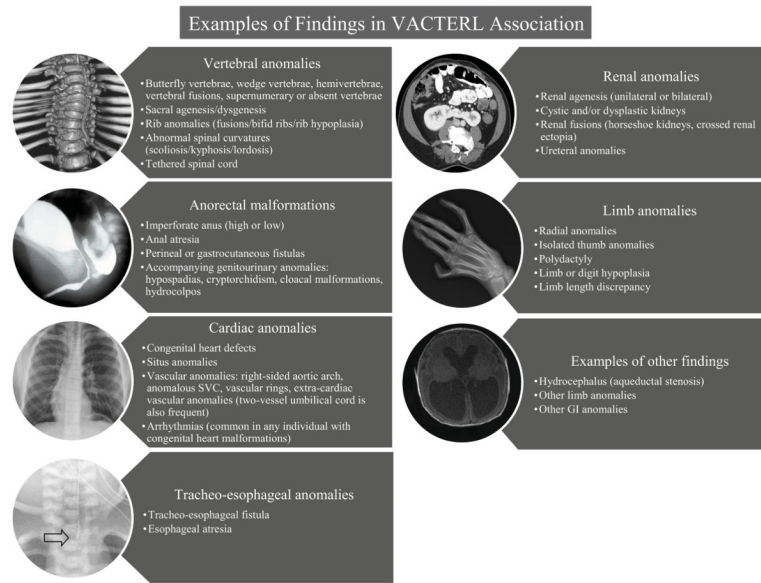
Examples of findings in VACTERL association. The images in the circles represent radiological examples of findings. Vertebral anomalies: 3-D CT reconstruction showing thoracic segmentation anomalies; Anorectal malformations: contrast imaging showing a rectoprostatic urethral fistula in a patient with an anorectal malformation; Cardiac anomalies: chest x-ray showing a midline heart in a patient with situs anomalies as part of VACTERL association; Tracheo-esophageal anomalies: x-ray showing the position of feeding tube placement (arrow) due to a tracheal pouch; Renal anomalies: axial view from an abdominal CT showing a horseshoe kidney; Limb anomalies: skeletal anomalies affecting the right radius, wrist, and thumb; Examples of other findings: axial view from a brain MRI showing hydrocephalus (due to aqueductal stenosis) Abbreviations: 3-D: three-dimensional; CT: computed tomography; GI: Gastrointestinal
